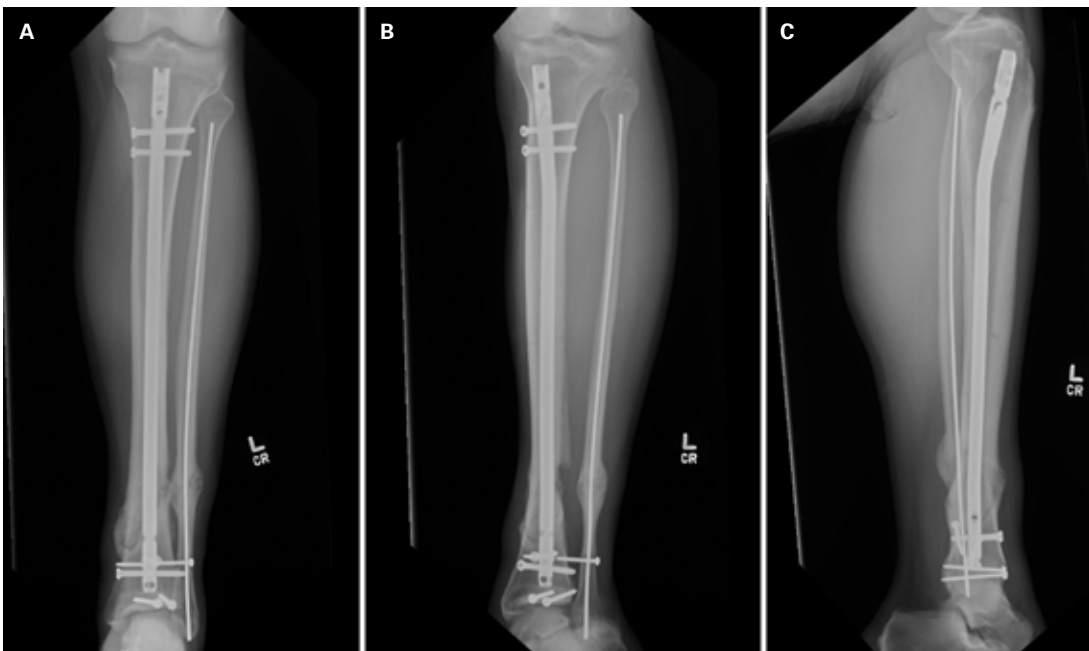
(A) Anteroposterior, (B) oblique, and (C) lateral radiographs of the left tibia/fibula six months postoperatively demonstrating interval healing at the distal tibia and fibula fracture sites. There is a fracture of the transyndesmotic screw noted.
